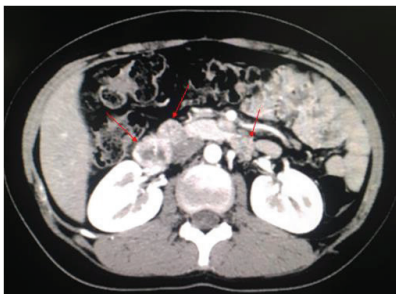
On the CT scan, two vascular-enhanced masses are seen at the level of the renal hilum, the right and left dimensions are 29 and 15 mm, respectively (red arrows).
